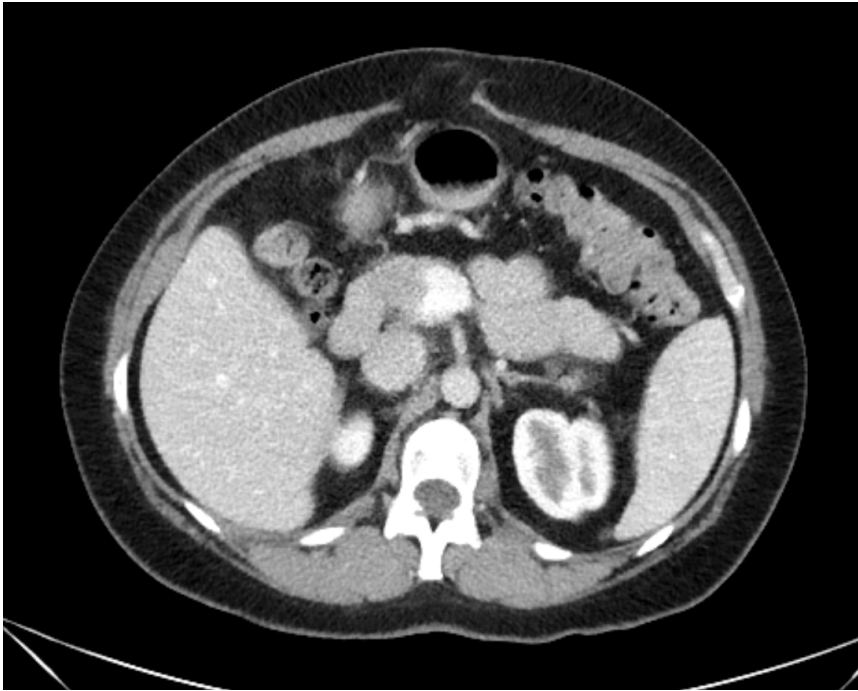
CT transversal plane image showing a typical midline incisional hernia.
